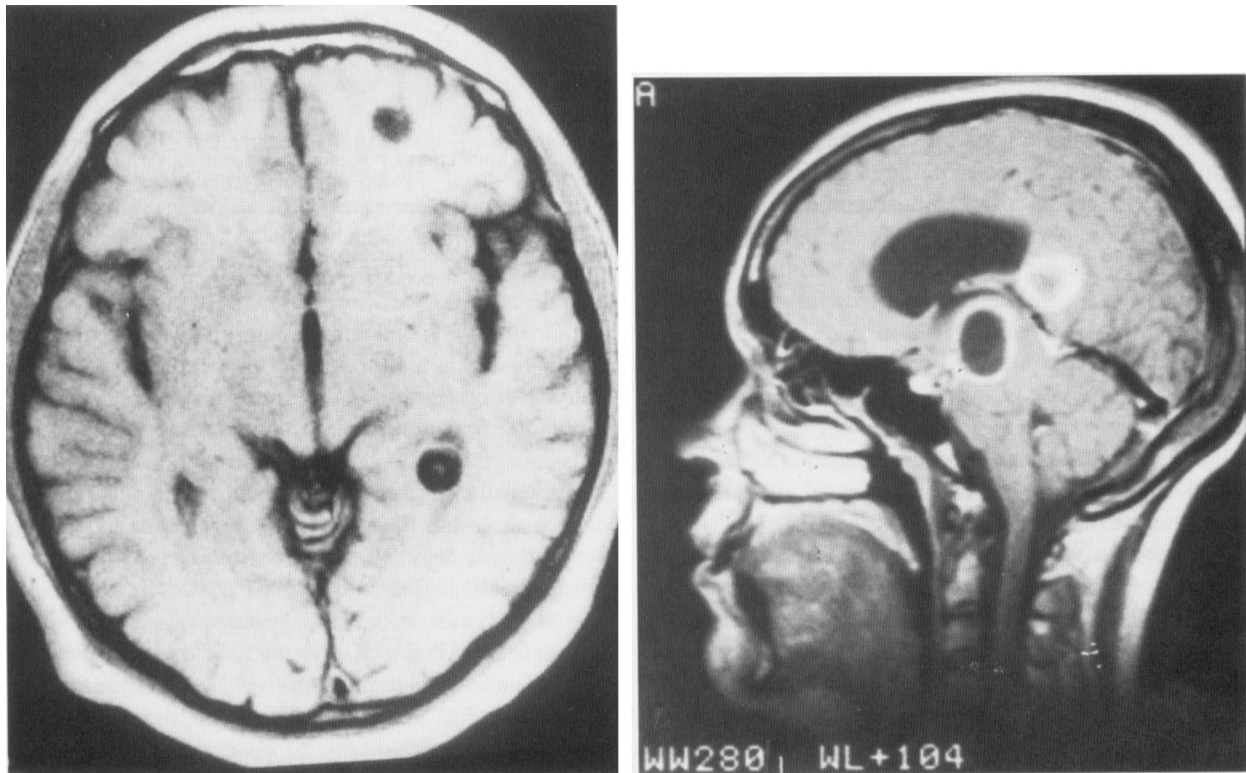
Typical images of cysticerci. Right: Computed tomography (CT) scan showing many active cysts with scoleces and calcifications in both hemispheres; a ring-enhancing (transitional) cyst on left thalamus. Left: A T<sub>1</sub>-weighted image showing viable active cyst with a clearly defined scolex with pedicle.
